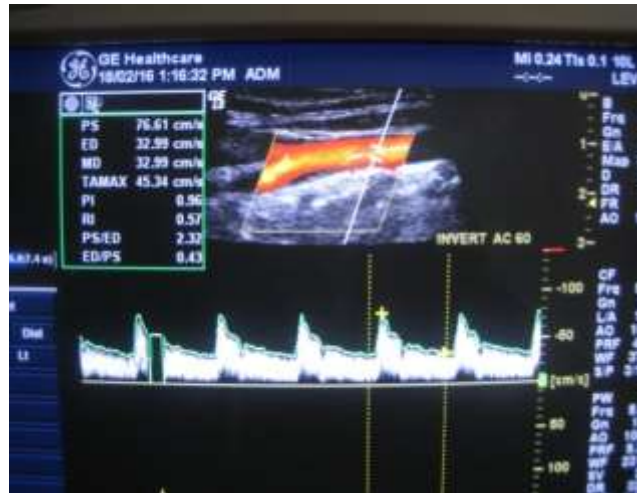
Doppler Color Image and Spectral Waveform of Common Carotid Artery
